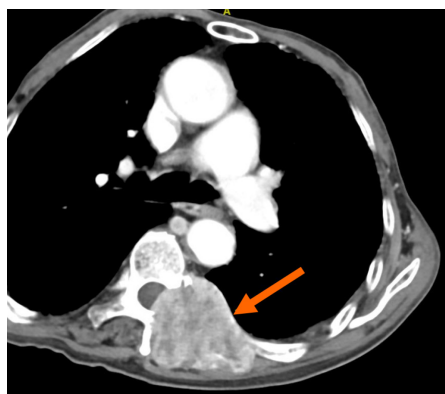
Computed tomography scan of metastatic lesions. The computed tomography scan shows thoracic vertebral metastatic lesions (orange arrow).
